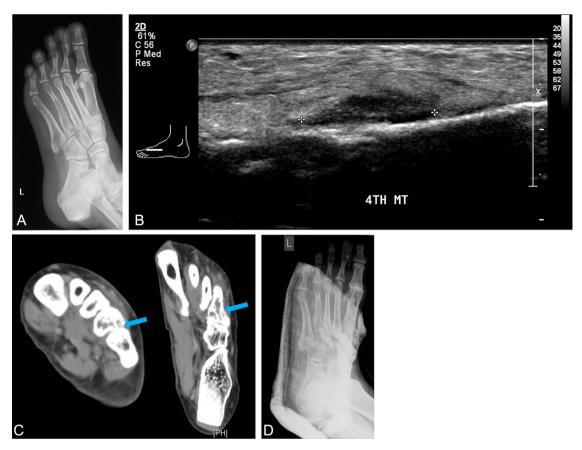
(A) Plain radiograph of the left foot showing an expansile osteolytic lesion in the diaphysis of the fourth metatarsal bone. There is periosteal reaction in the proximal diaphyseal region. (B) Ultrasonography showing diffuse subcutaneous edema in the dorsum of left foot. There are cortical irregularities along the mid-shaft of left fourth metatarsal bone, associated with surrounding periosteal collection. (C) Coronal (left) and transverse (right) CT images showing medullary expansion along the shaft and base of the left fourth metatarsal bone with cortical irregularities (right arrow) and defects suggestive of cloaca (left arrow). (D) Plain radiograph of the left foot showing minimally displaced fracture in the anterior aspect of the osteolytic lesion in the diaphysis of the fourth metatarsal.
